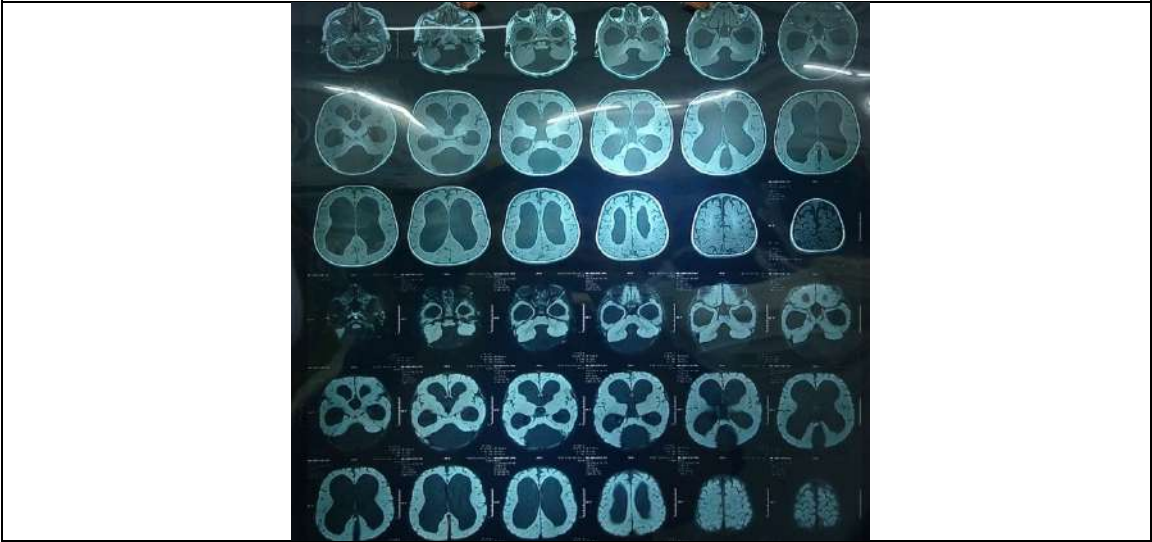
MRI scan of the patient demonstrating Dandy walker malformation and Hydrocephalus
